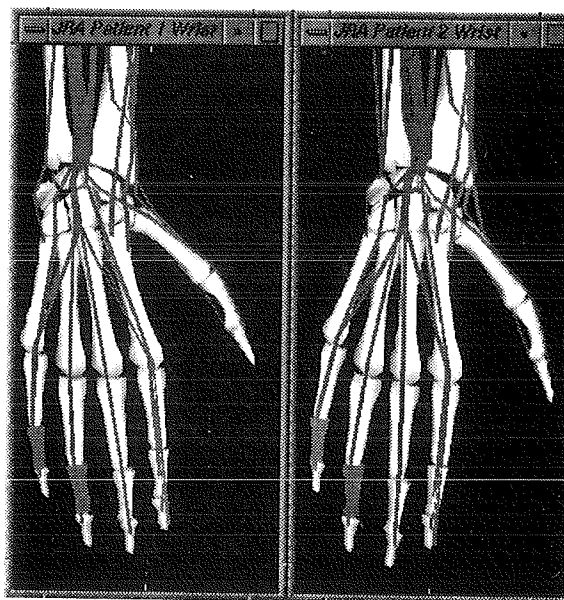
Graphical models of two maligned wrists developed from anterior-posterior x-ray images of children with juvenile rheumatoid arthritis. Left wrist is JRA patient 1 and right wrist is JRA patient 2. Graphical models were developed on SIMM (Delp *et al.*, 1995).
